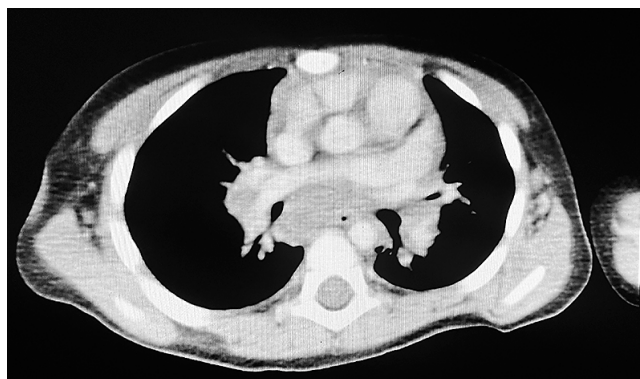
CT of the chest – interstitial window. Visible enlargement of the mediastinal lymph nodes
